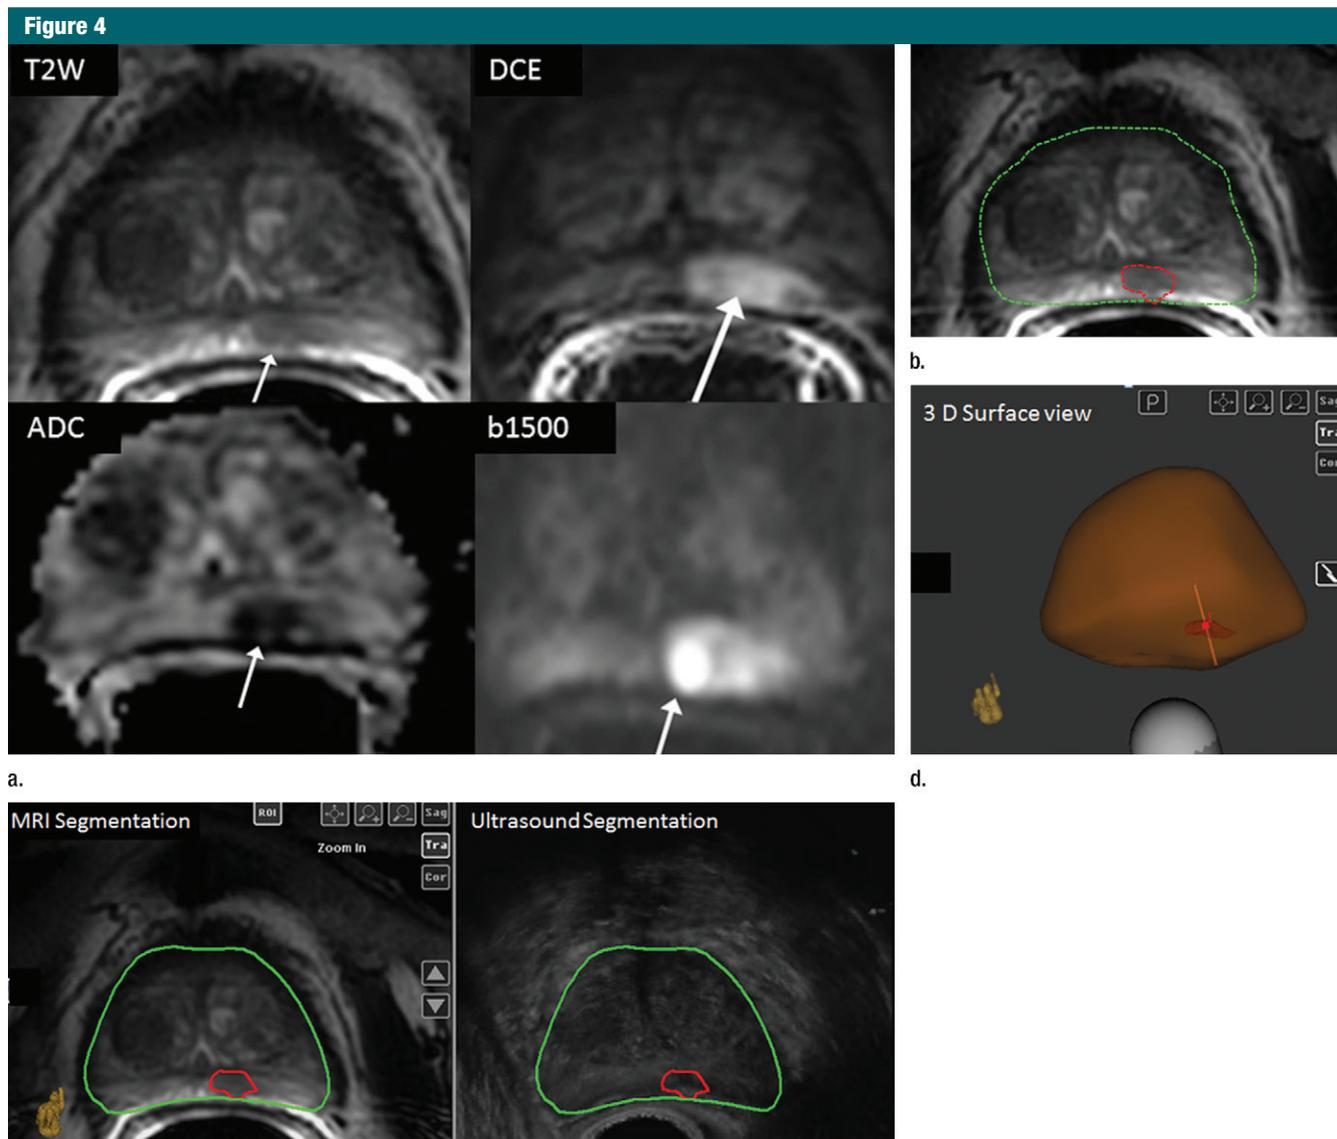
Images in a 68-year-old man with rising PSA to 9.9 ng/mL and two negative transrectal US prostate biopsy findings. (a) A 10-mm poorly marginated nodule in left mid gland peripheral zone (arrow) with decreased T2-weighted signal intensity, decreased apparent diffusion coefficient of $0.773 \times 10^{-3} \text{ mm}^2/\text{sec}$, increased high-*b*-value signal of 1500, and focal early enhancement on dynamic contrast-enhanced images yielding an overall score of 4 on PI-RADS version 2. (b) Prostate segmentation is performed by using MR imaging data set to produce a three-dimensional model of the prostate. The prostate (green circle) is outlined by using a semiautomated segmentation tool and delineated as a target (red circle). (c) During fusion biopsy, real-time three-dimensional US model of the prostate is acquired and used to outline the prostate (green circle). The MR imaging and transrectal US three-dimensional models are dynamically fused and visualized side by side. This data set facilitates transrectal US–MR imaging registration and allows projection of the suspicious area seen at MR imaging (red circle) on the transrectal US screen. (d) Finally, targeted biopsies can be performed to generate a final three-dimensional model. Targeted biopsy demonstrated a tumor with Gleason score of 3 + 4. Follow-up prostatectomy confirmed transrectal US–MR imaging fusion biopsy findings. *T2W* = T2-weighted. *DCE* = dynamic contrast enhanced. *ADC* = apparent diffusion coefficient. *3D* = three-dimensional.
